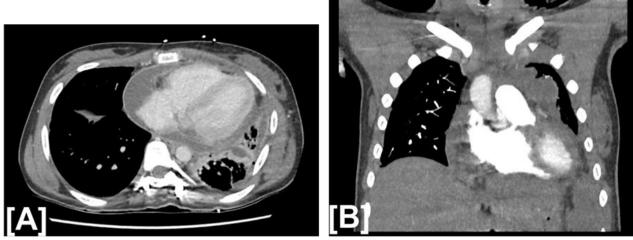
Axial [A] and coronal [B] slides of CT scan performed on day 14 of admission showing new haemopericardium.
